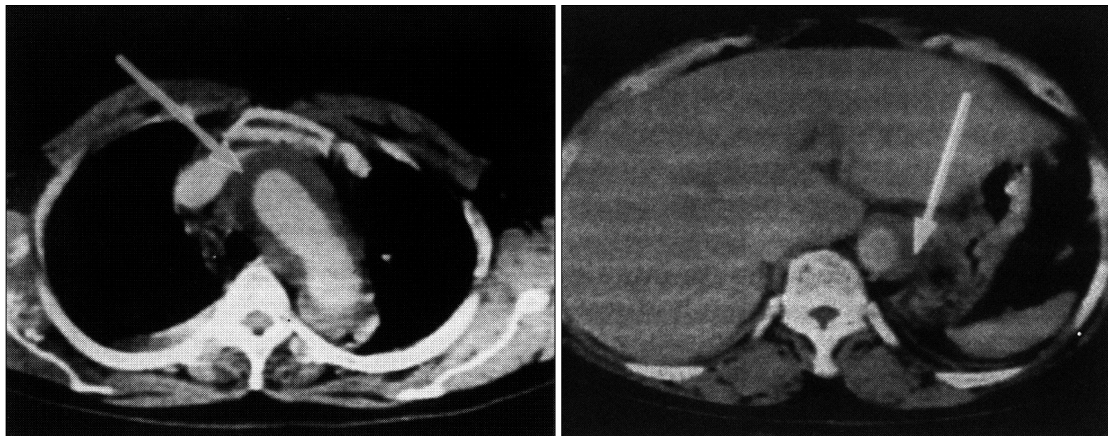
Contrast enhanced computed tomography shows type A aortic dissection, arrow(false lumen).
